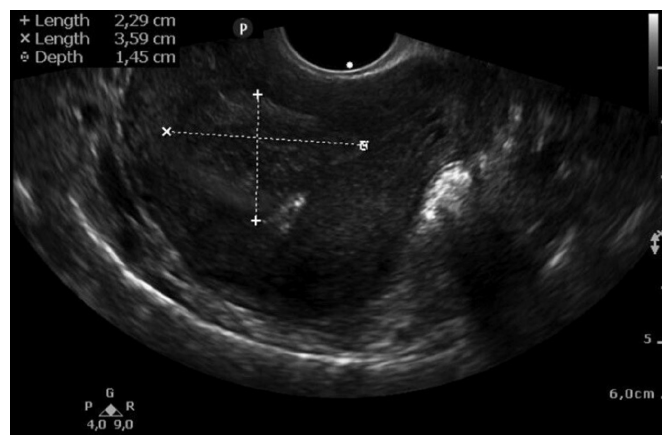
Transvaginal ultrasound showing the fibroid after treatment with the Sonata system, reduced in size and expelled into the uterine cavity.
